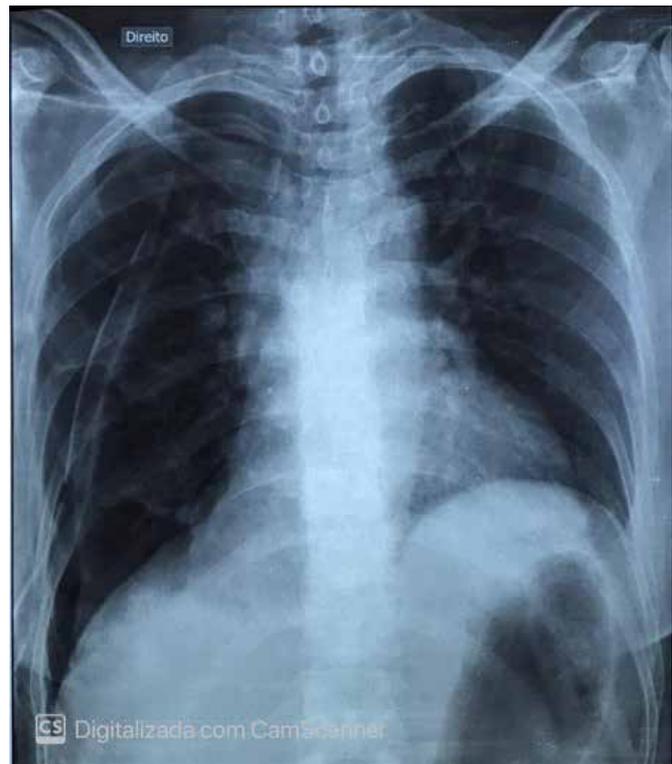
Anteroposterior chest x-ray in the immediate postoperative period of laparoscopic pleuroscopy, pleurodesis with sterile talc, pleural biopsy and thoracoscopy with closed pleural water seal drainage.
